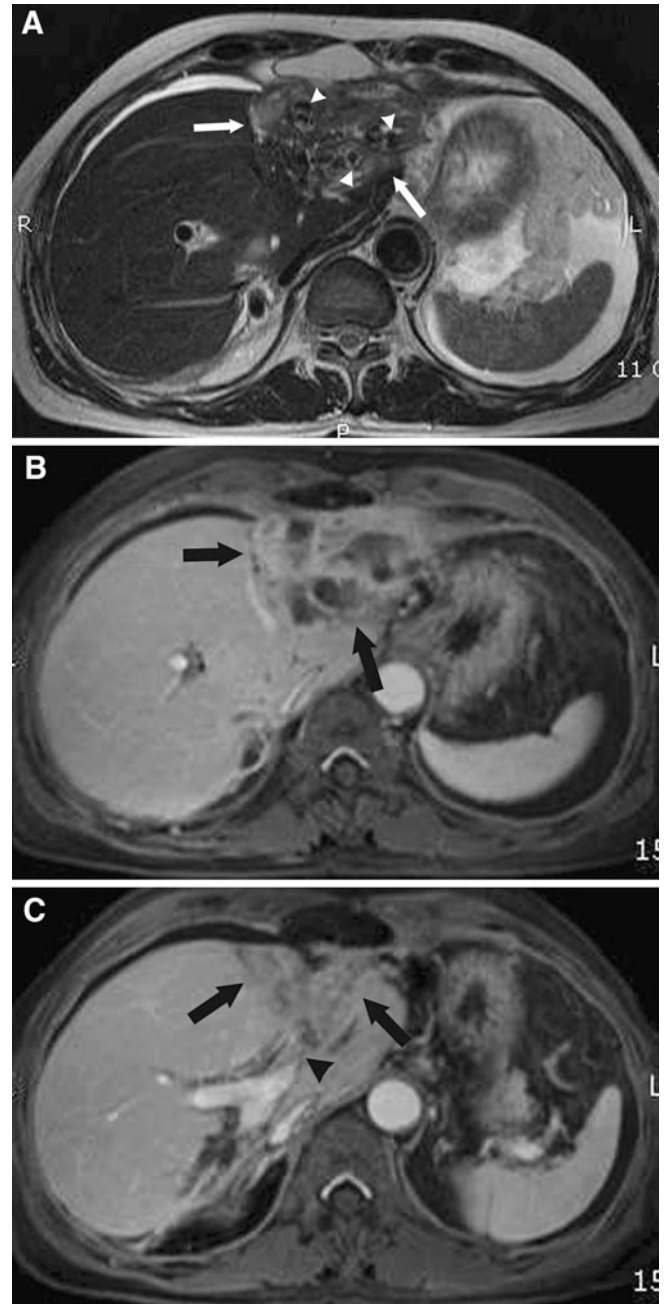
Cholangiocarcinoma associated with RPC in a 67-year-old man who complained of abdominal pain, fever, and leukocytosis. He had a history of recurrent attacks of the cholangitis and clonorchis sinensis infestation. A T2-weighted TSE MR image demonstrates slightly high-signal intensity mass (*arrows*) in the lateral segment of the left lobe. There are hepatolithiasis within the intrahepatic duct (*arrowheads*). B, C Contrast-enhanced MR images during the portal phase show an ill-defined enhancement of the mass (*arrows*). The mass located in the same lobe as the portal vein obliteration (*arrowhead*). The diagnosis of cholangiocarcinoma was made by surgical resection.
